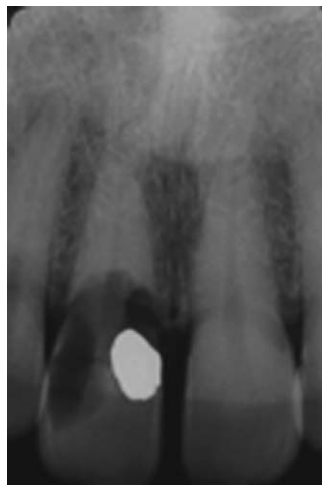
Preoperative radiograph of tooth #8 with internal resorption.
